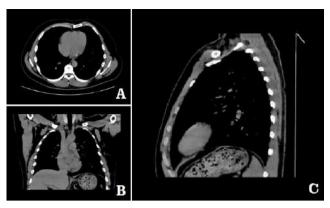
CT examination of chest wall before operation.
